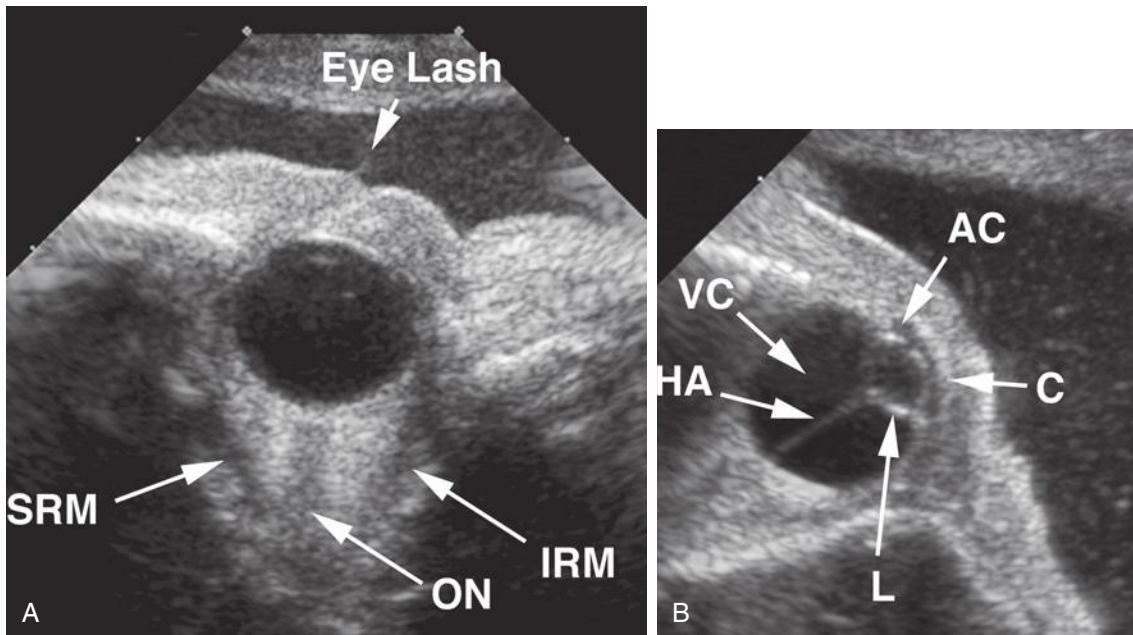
Fetal orbits and contents seen on parasagittal sonograms (A and B). AC, anterior chamber; C, cornea; HA, hyaloid artery; IRM, inferior rectus muscle; L, lens; ON, optic nerve (traversing the retrobulbar fat); SRM, superior rectus muscle; VC, primary vitreous. Note the eyelash extending from the closed eyelids (also visible in B).
